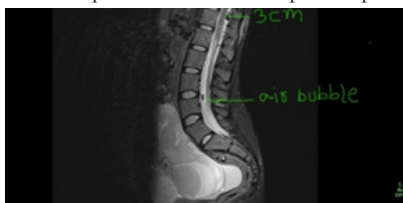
MRI spine showing air bubbles
